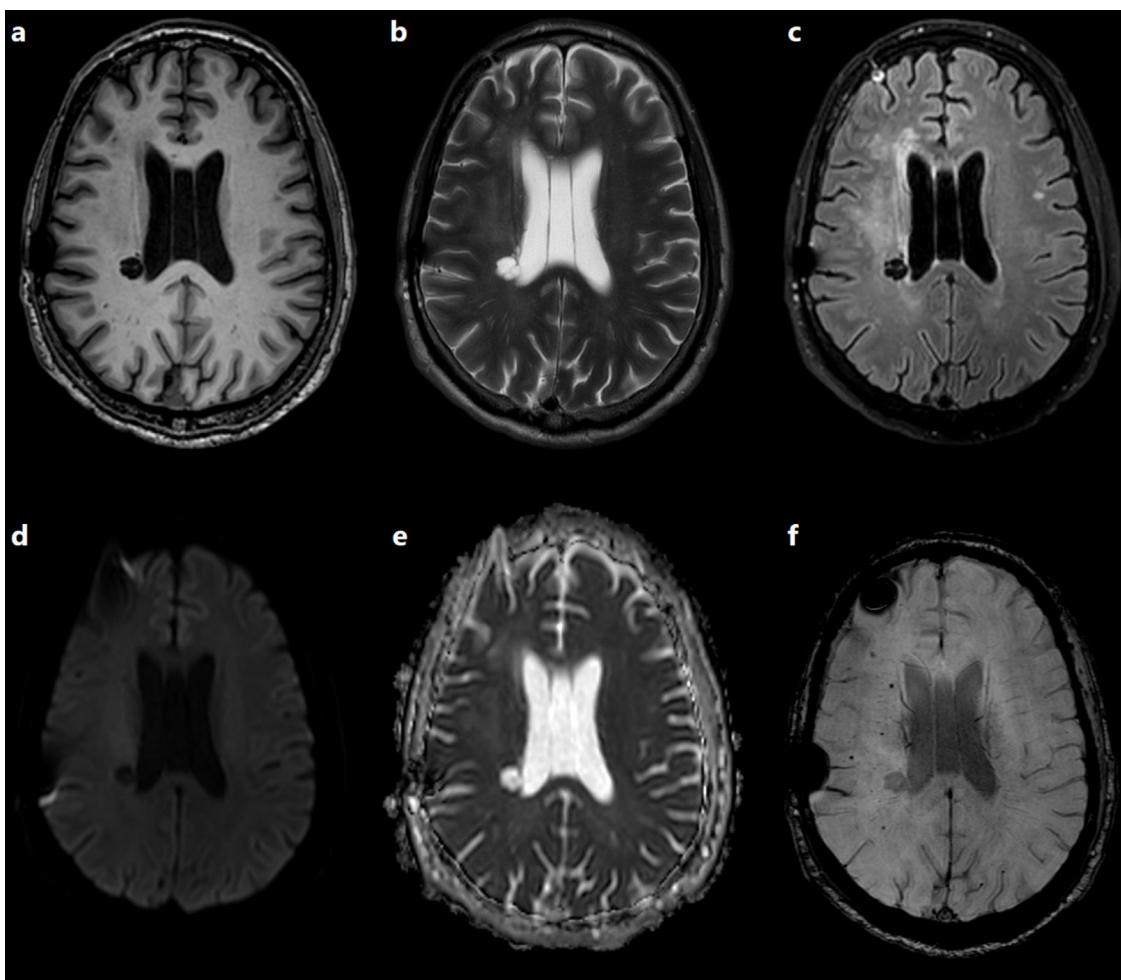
Status of the lesion in an MRI study performed in 2020. a) Non-contrast T1-weighted 3D-SPGR sequence; b) T2-weighted TSE sequence; c) 3D T2-FLAIR sequence; d) diffusion sequence ($b = 1000$); e) ADC map; f) magnetic susceptibility sequence. The lesion is isointense to CSF on T1- and T2-weighted sequences (a, b), and presents signal suppression on T2-FLAIR sequences (c), which suggests free water in the centre and absence of peripheral oedema or gliosis; it also presents facilitated diffusion (d, e). The magnetic susceptibility sequence shows hypointense haemorrhagic foci near the lesion, within the radiation field (f).
